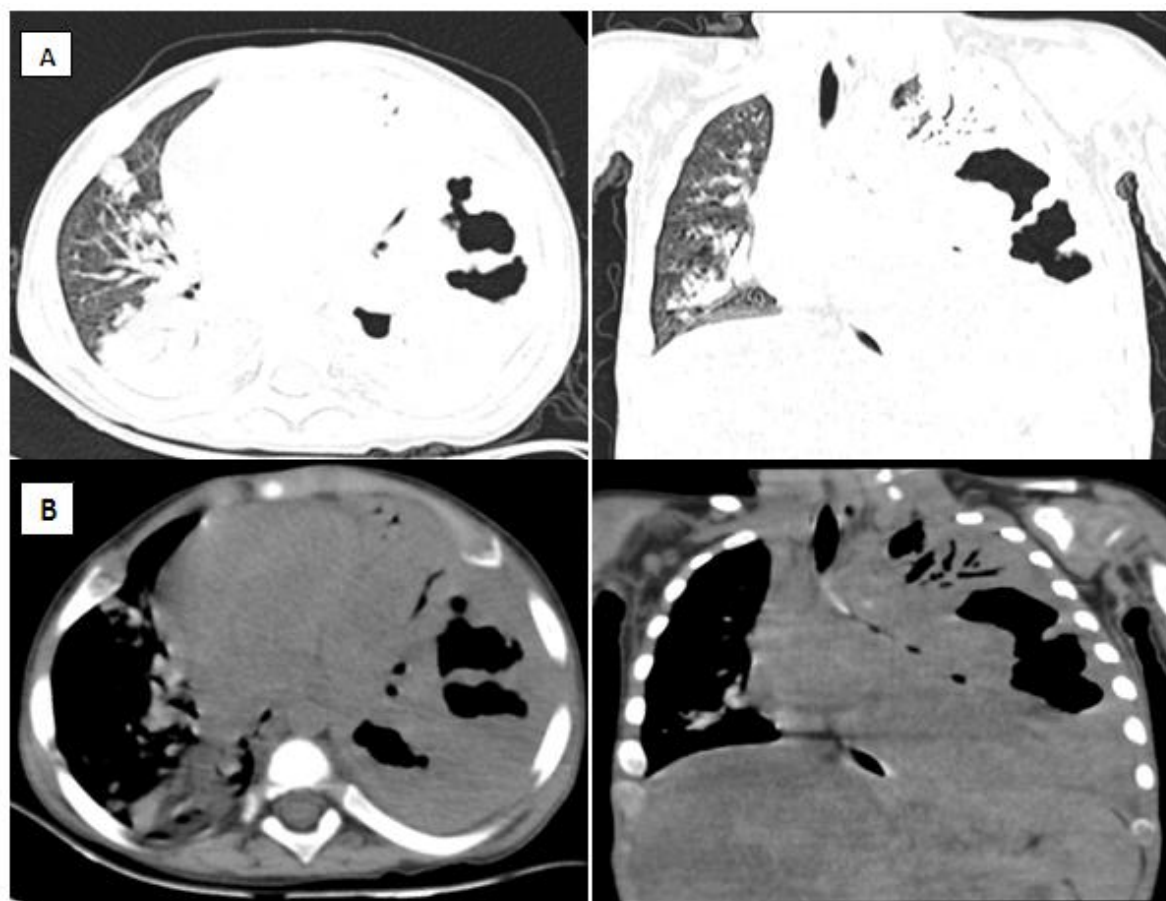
(A) Axial (left image) and coronal HRCT chest lung window showed multiple centrilobular branching opacities in V-Y pattern (tree in bud pattern) with diffuse areas of air space consolidation involving bilateral lung parenchyma (left > right) with few variable sized thick walled cavitary changes. (B) Axial (left Image) and coronal CT chest soft tissue window showed areas of air space consolidation with cavitary changes involving left lung parenchyma.
